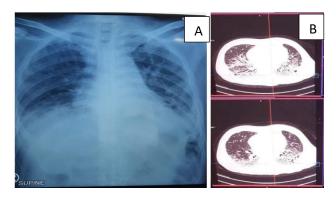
A) Chest X-ray of a pneumonia and B) CT scan of the thorax and results showed interstitial lung pneumonia.
